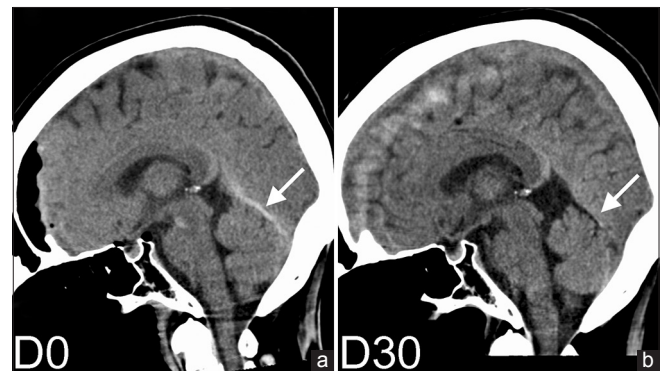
Sagittal plane computed tomography images immediately after the operation (a) and at 1 month after the operation (b). Arrows indicate the straight sinus. Hyperdensity in the straight sinus resolved spontaneously
